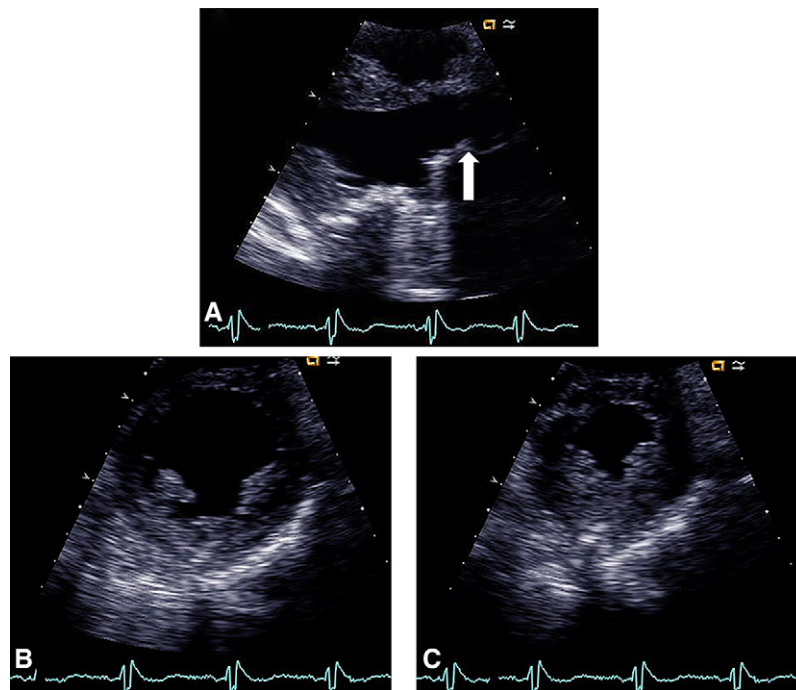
Echocardiographic evaluation 32 years after homograft total aortic root replacement showing (A) a long-axis view of the left ventricular outflow tract and aortic root with good opening of the valve (*arrow*) and sinus expansion, (B) short-axis end-diastolic view of the left ventricle, and (C) end-systolic view of the left ventricle showing good ventricular function.
